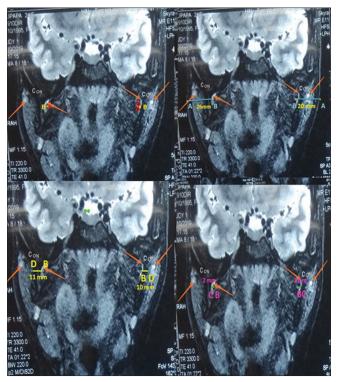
Coronal section of MRI Showing- B/L TMJ ankylosis-Right side and Left side Condyles (CON-Orange arrow). Point B, Distance AB-Blue line, Distance CB-Pink line and Distance DB-Yellow line, TMJ: Temporomandibular joint, MRI: Magnetic resonance imaging
